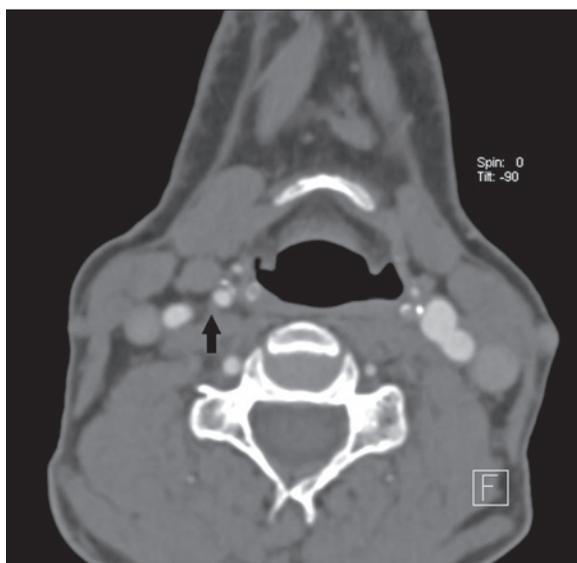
CTA examination of the carotid arteries. Axial projection. Standard protocol – beginning of acquisition: 60s from the moment of administering intravenous contrast agent.
